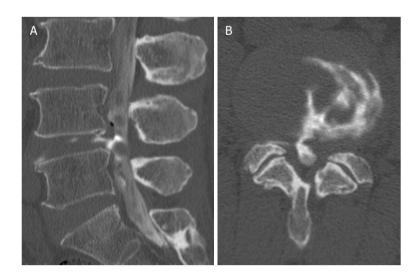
Computed tomography after discography. A: sagittal image; B: axial image
